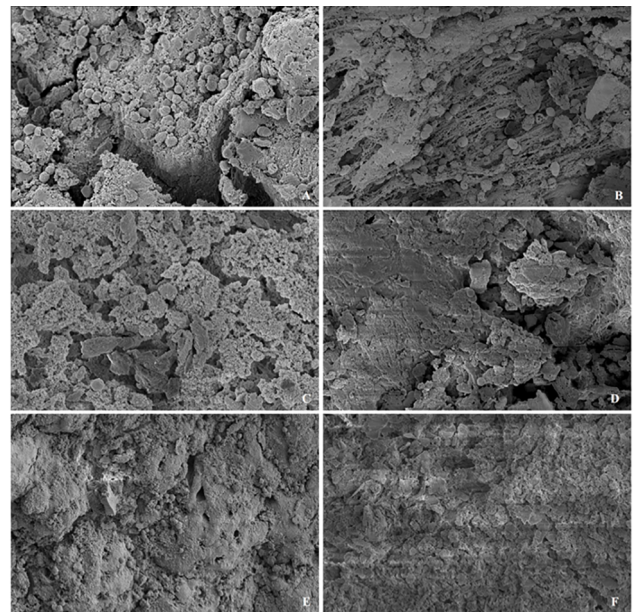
(A, B) Untreated positive controls (5000 \times); (C) sample from ProTaper Gold group with passive ultrasonic activation (PUI) (8000 \times) showing no microorganisms; (D) sample from ProTaper Gold group without PUI (5000 \times) showing few microorganisms; (E) sample from WaveOne Gold without PUI (2500 \times) showing few microorganisms; (F) sample from WaveOne Gold with PUI (2500 \times) showing few microorganisms.
